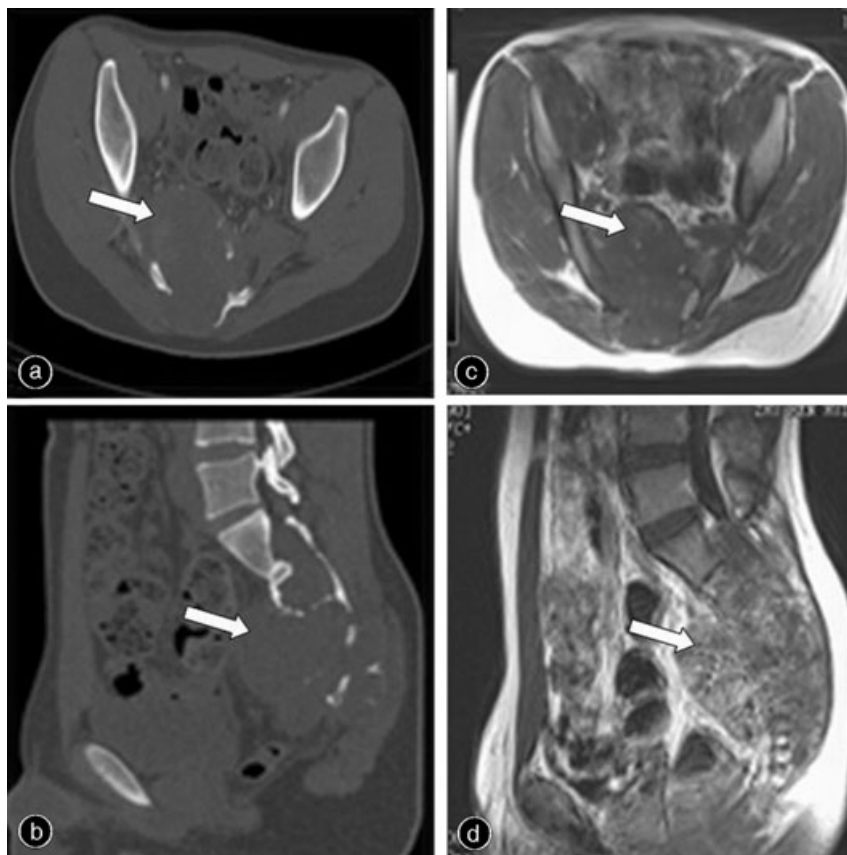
(a) and (b): Preoperative CT image of a 54-year-old man shows a sacral chordoma, with lytic bone destruction of the osseous pelvis. (c) and (d): Preoperative T₁-weighted MR image shows the tumor affecting the entire sacrum with a soft tissue mass covered anteriorly by the pre-sacral fascia.
